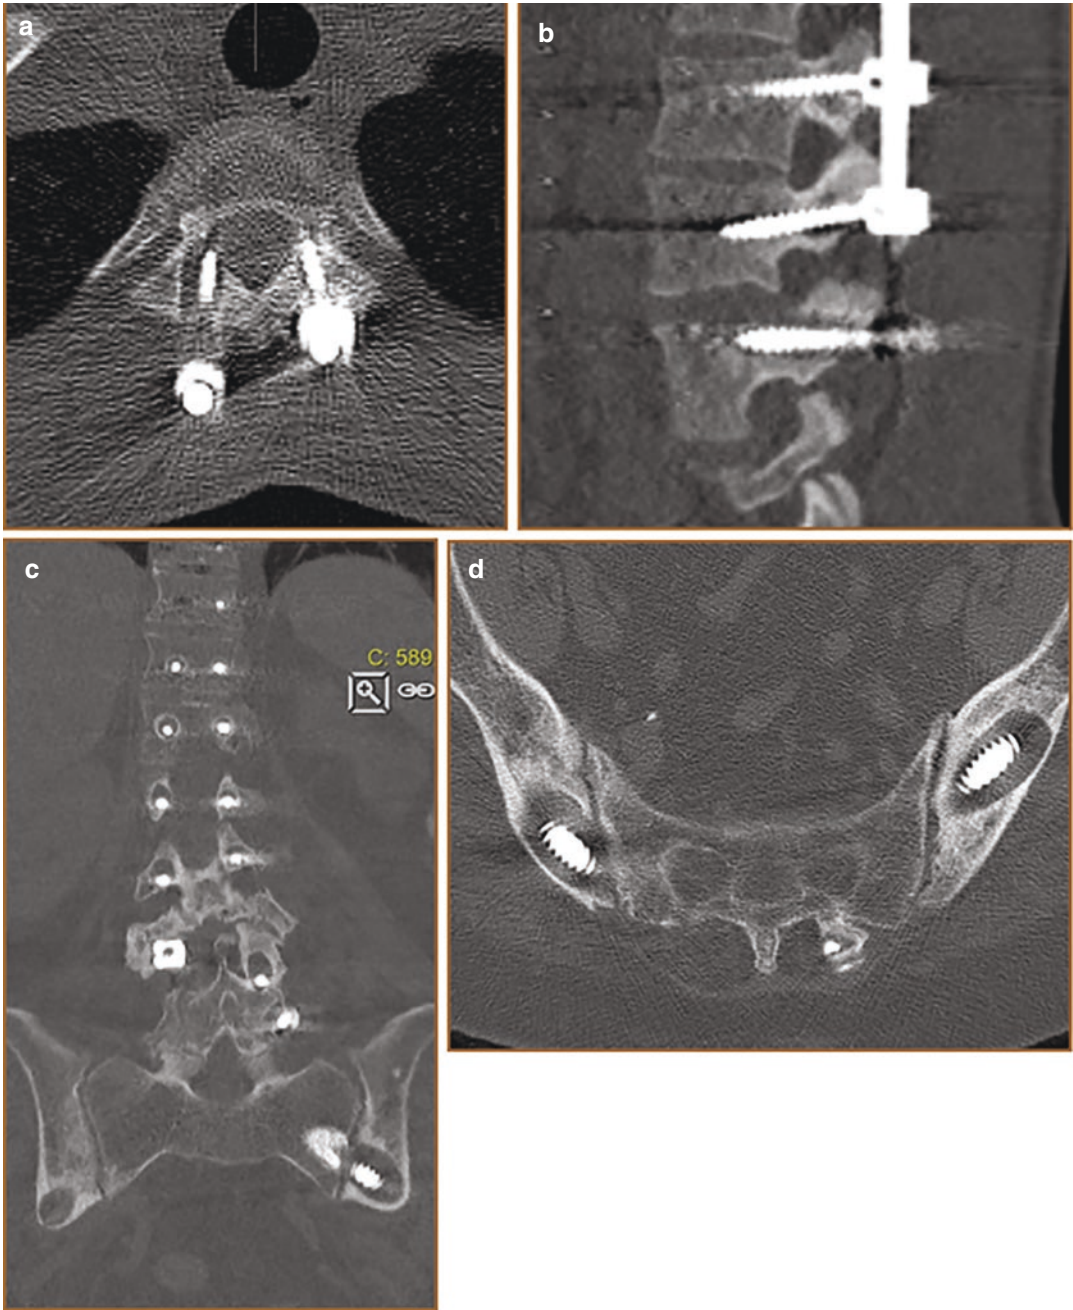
(a–d) Loss hardware. Axial (a) and sagittal (b) low-dose CT demonstrating halo around screws as a sign of loss implants. These halo zones around the screws can be gigantic (c, d) as seen in the lower lumbar and sacral spine
